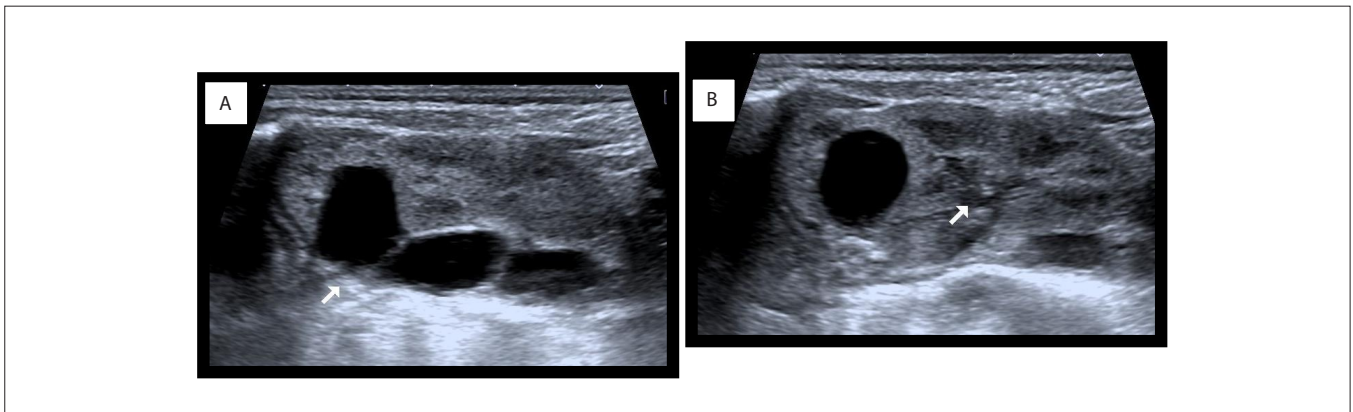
Ultrasound images of a left duplex collecting system with a dilated upper moiety (A) and an undilated lower moiety (B) of the left kidney.
